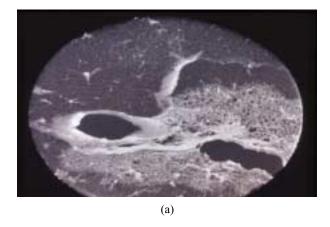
3-D display of the stacked Micro CT images of the abnormal lung tissue (peripheral type of lung adenocarcinoma) Resolution: $24~\mu m$. (b) Resolution: $6~\mu m$.
